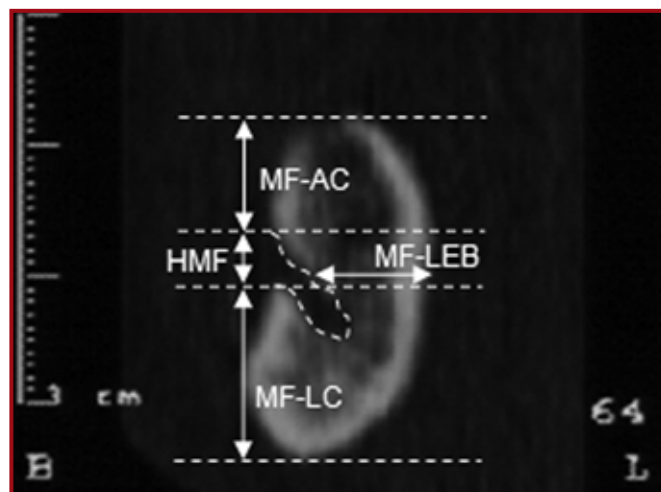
The evaluation of mental foramen in cross-sectional CT images: MF-AC: Mental foramen to alveolar crest. MF-LC: Mental foramen to lower cortex. HMF: The height of mental foramen. MF-LEB: Mental foramen to lingual external border
